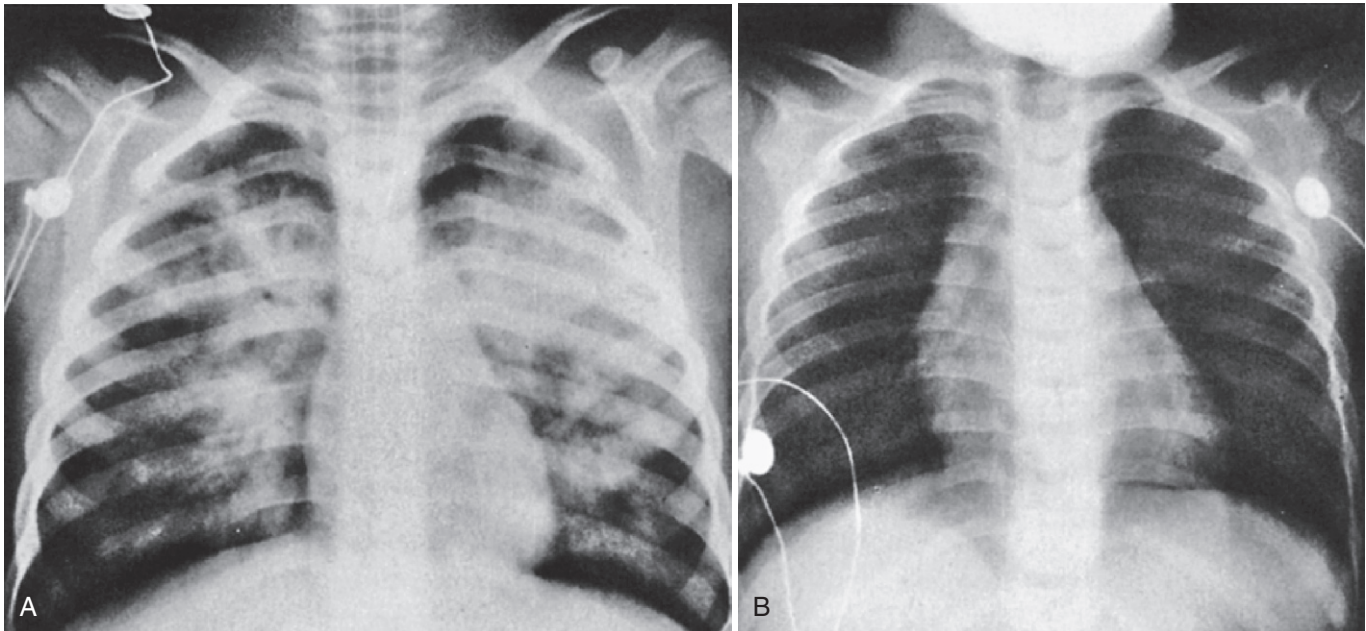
Drowning with and without aspiration. Radiographs show a patient with severe pulmonary edema (A), and another without significant fluid aspiration (B). (From Ciullo JV, editor: *Clinics in sports medicine*, Philadelphia, 1986, WB Saunders.)
